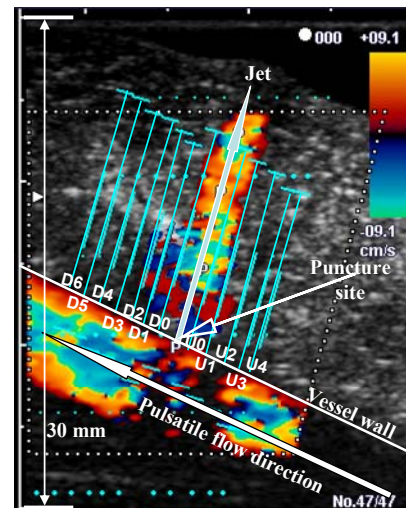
Color Doppler image of a punctured vessel.
